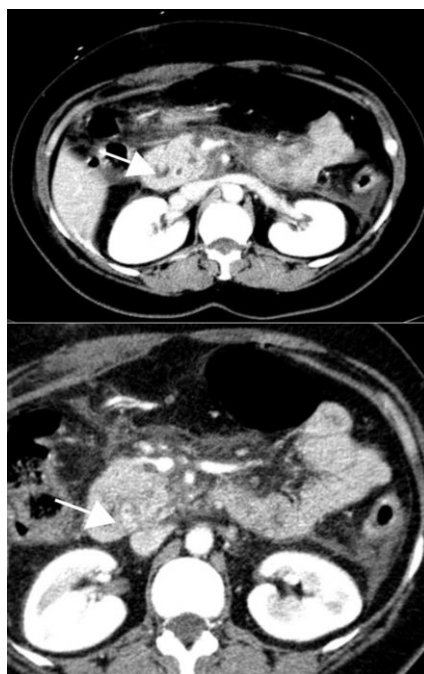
Abdominal computed tomography (showing the duodenal lumen (arrow) into the pancreatic head.
